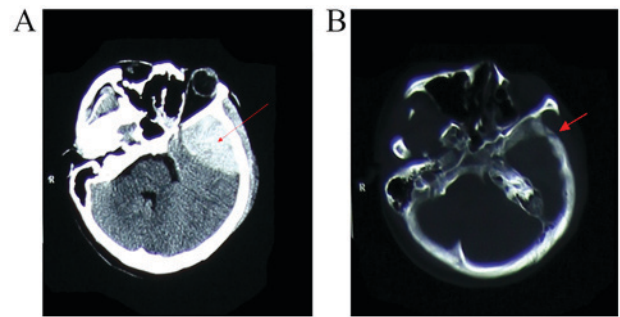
Brain computed tomogram on admission, revealing (A) an epidural hematoma in the left temporal lobe (arrow) and (B) a fracture line through the temporal bone (arrow).
